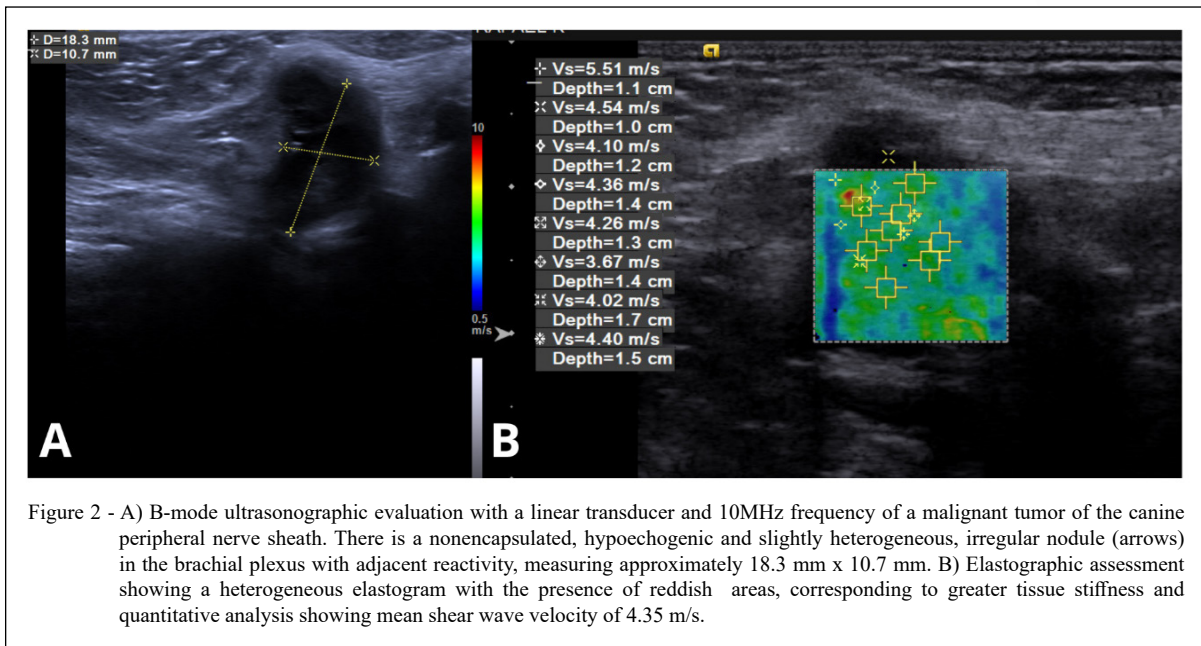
A) B-mode ultrasonographic evaluation with a linear transducer and 10MHz frequency of a malignant tumor of the canine peripheral nerve sheath. There is a nonencapsulated, hypoechoic and slightly heterogeneous, irregular nodule (arrows) in the brachial plexus with adjacent reactivity, measuring approximately 18.3 mm x 10.7 mm. B) Elastographic assessment showing a heterogeneous elastogram with the presence of reddish areas, corresponding to greater tissue stiffness and quantitative analysis showing mean shear wave velocity of 4.35 m/s.
